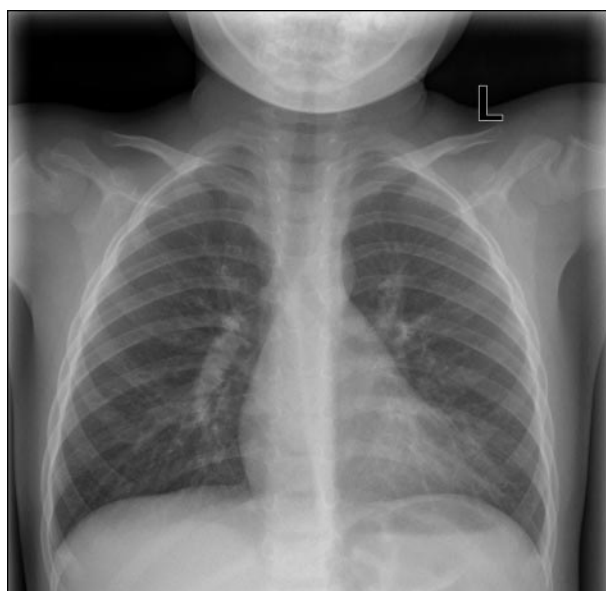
Radiographic findings of viral pneumonia caused by respiratory syncytial virus: Hyperinflation, mild peribronchial cuffing, increased parahilar markings, and patchy lingular opacity (note the loss of the left heart border on the frontal view), likely representing atelectasis.
